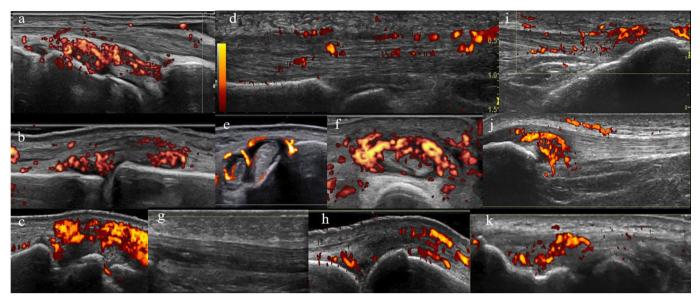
Spectrum of ultrasound-detected inflammatory changes and structural damage across joints, tendons and entheses in patients with ICI-arthritis and ICI-arthralgia. (a) Wrist synovitis (radio-carpal and intercarpal joints). (b) Third metacarpophalangeal joint synovitis. (c) Active synovitis of the second metacarpophalangeal joint with bone erosion on the medial side of the metacarpal head. (d) Second finger flexor tendon tenosynovitis. (e) Peroneal brevis and longus tendon tenosynovitis. (f) Extensor carpi ulnaris tenosynovitis. (g) Focal discontinuity of the peroneal brevis tendon consistent with partial rupture. (h) Synovitis of the second metacarpophalangeal joint and extensor finger tendon peri-tendinitis. (i) Active enthesitis of the distal patellar tendon. (j) Active enthesitis of the proximal patellar tendon. (k) Active enthesitis of the extensor tendons of the forearm. ICI, immune checkpoint inhibitor.
